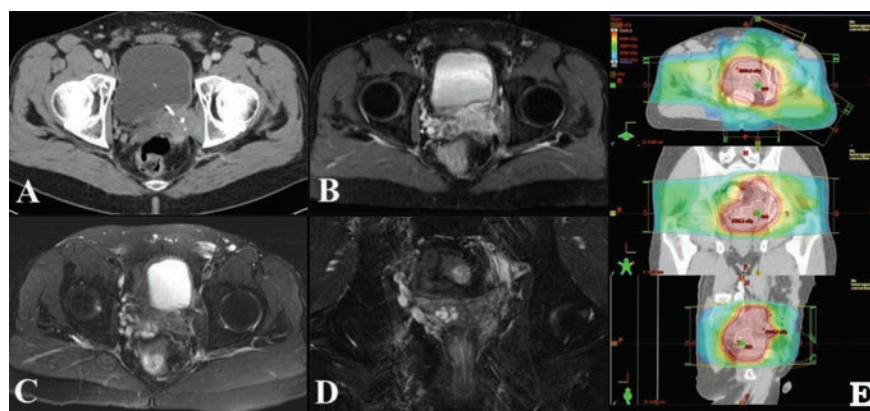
Imaging studies at the time of initial presentation show a mass emanating from the left seminal vesicle and invading the left posterior bladder wall and the left obturator internus muscle. The mass demonstrates contrast enhancement on axial computed tomography (A) and magnetic resonance imaging (B). The mass is hypointense on T2 weighted axial (C) and coronal (D) magnetic resonance imaging. (E) Pre-operative external beam radiotherapy plan with a prescribed dose of 50 Gray delivered in 25 fractions. The gross tumor volume (GTV) is delineated in white outline and the planning target volume (PTV) is delineated in black outline. The GTV, representing the tumor as visualized on CT and MRI, was expanded by 1.5 cm to generate the clinical tumor volume (CTV). The CTV was expanded by 0.7 cm to generate the PTV.
